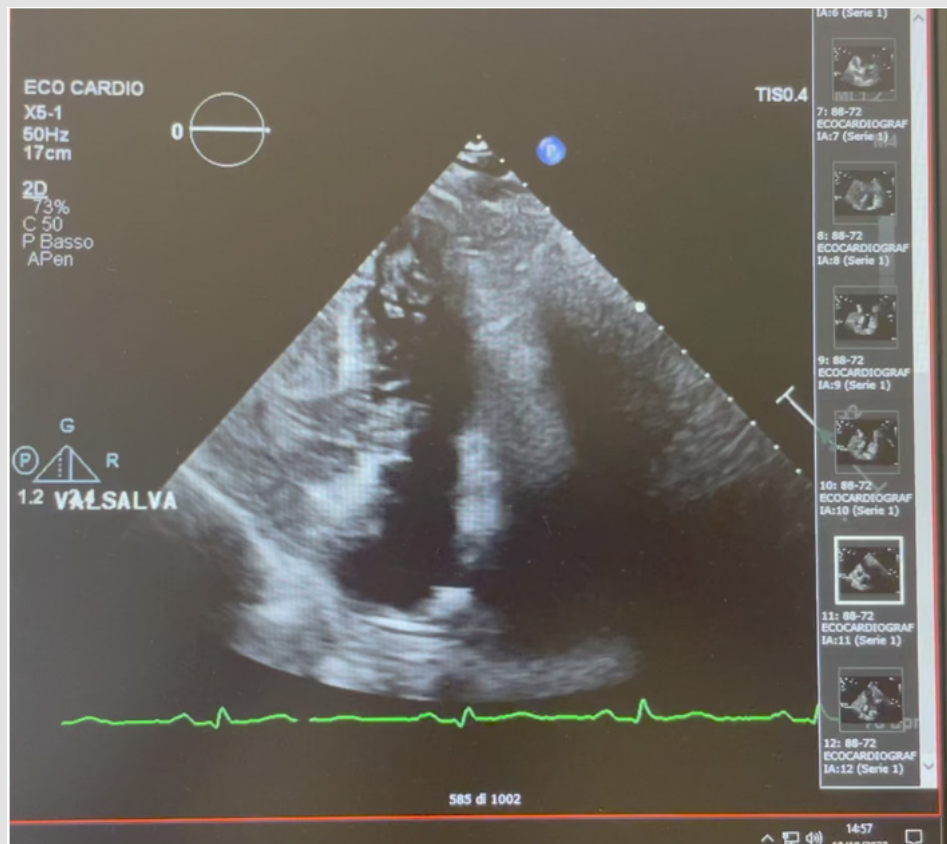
Transthoracic echo-cardiogram with bubble contrast showed the presence of right-to-left shunt through patent foramen ovale. LA left atrium, RA right atrium, LV Left ventricle.
